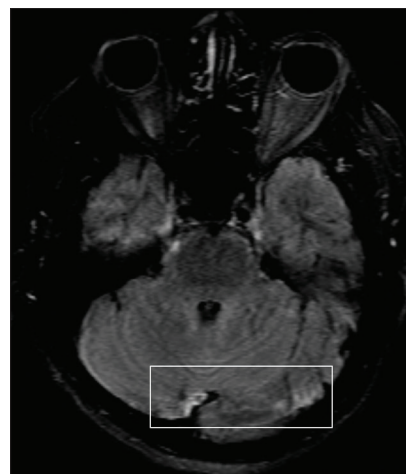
Magnetic resonance imaging brain showing meningeal enhancement in bilateral cerebellar regions
